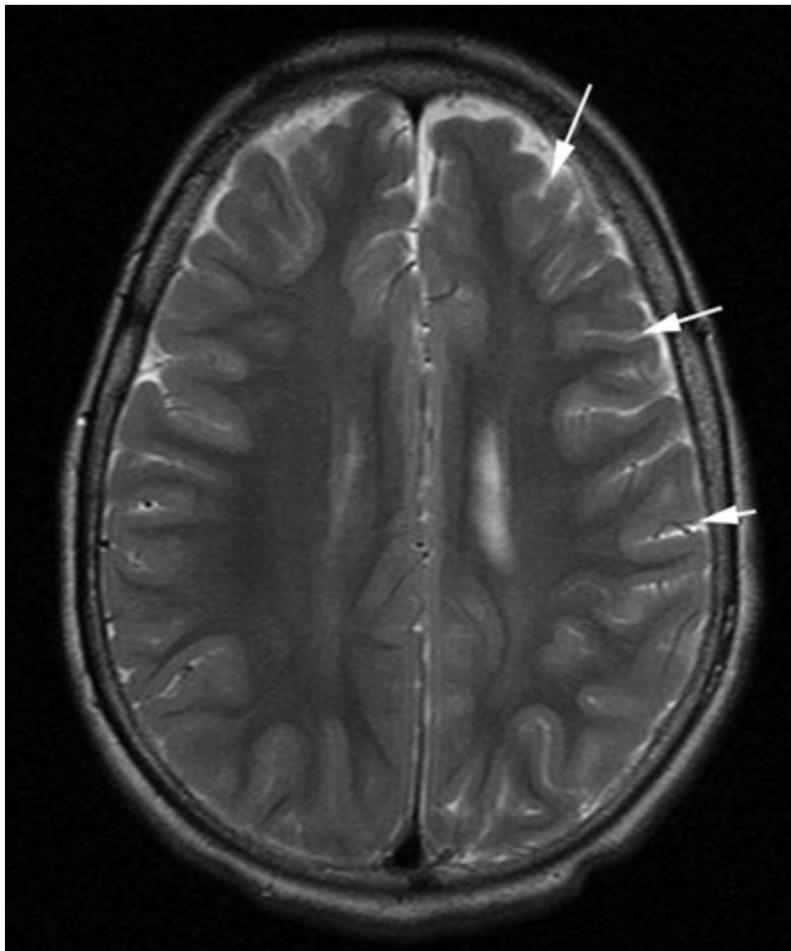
Rasmussen encephalitis. Axial T2-weighted image from MRI without gadolinium in a 3-year-old boy with a 1-year history of right tonic–clonic seizures progressive hemiparesis shows widening of the left frontal sulcal markings consistent with mild volume loss (arrows). Rasmussen encephalitis typically presents with intractable partial seizures (usually focal motor seizures and epilepsy partialis continua), progressive hemiparesis, cognitive decline, and unilateral cerebral atrophy with early and prominent involvement of the insular region.
